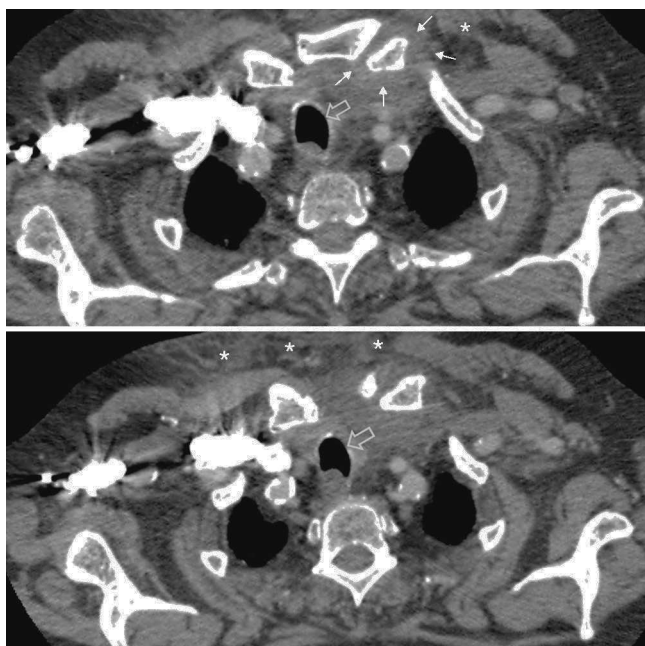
Case 4. Two sequential sections of the upper thoracic CT. Limits of the articular capsule (white arrows), involvement of subcutaneous soft tissue (asterisks) and deviation of the airway (open arrow) can be seen.
